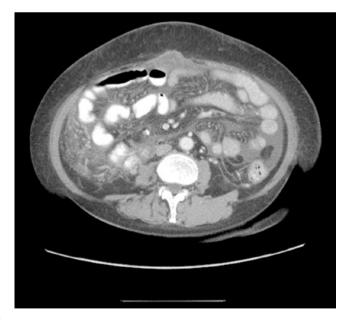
Computed tomography of tuberculous colitis with dissemination into the peritoneal cavity with ascites and omental infiltration (axial view)
